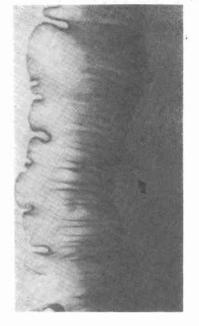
X-ray; typical pericolic reaction between posterior rectal wall (→) and Os sacrum (←).
